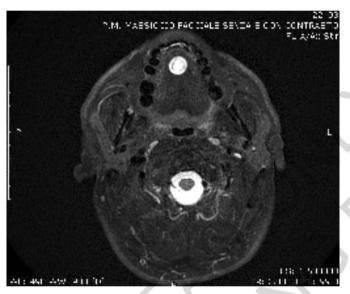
Pre-operative axial STIR MRI reveals a well-defined hyperintense mass.
